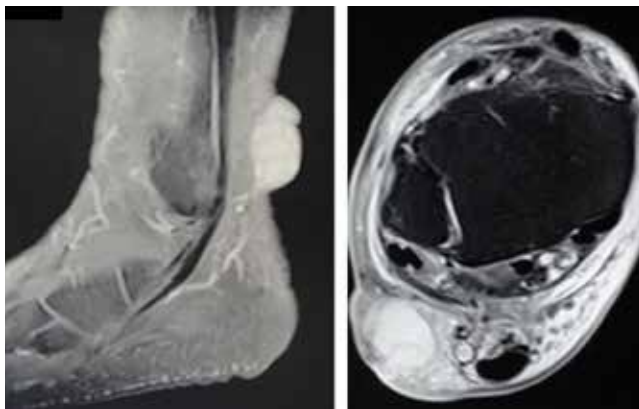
Magnetic resonance imaging of the ankle showing expansive lesion with defined boundaries centered in the subcutaneous plane
